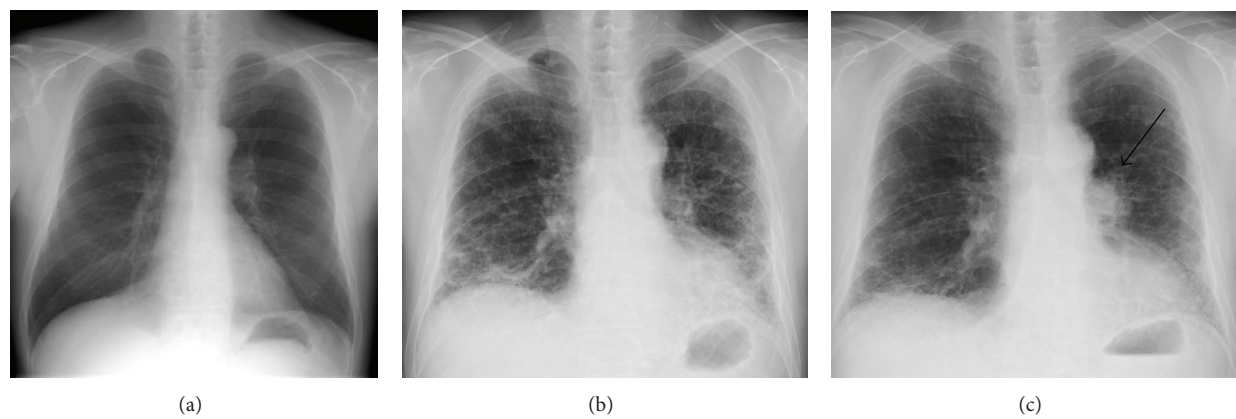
Chest X-ray at the onset of DM (a). Chest X-ray at the deterioration of IP 11 years after the onset of DM (b). X-ray at the lung cancer diagnosis 13 years after the onset of DM (c).
